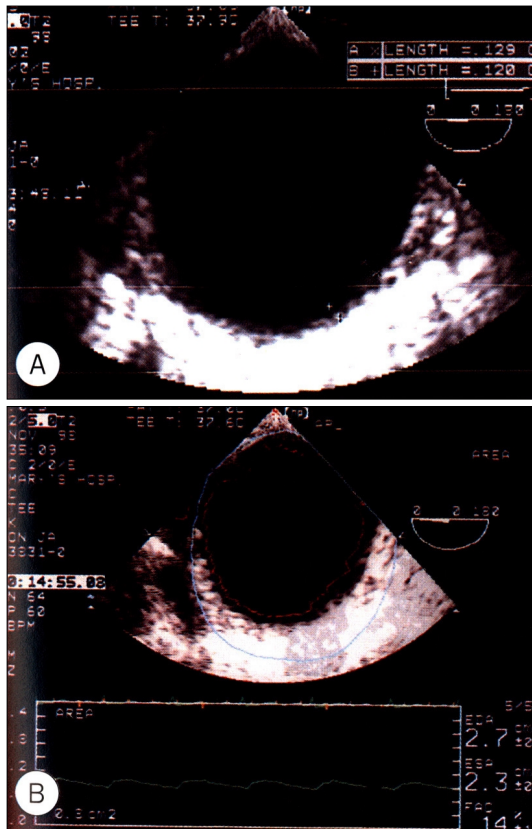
Transesophageal echocardiographic findings of descending aorta in 58 year-old control woman. A : The intimal-medial thickness of descending thoracic aorta was about 1.2 mm. B : Fractional area change of this patient measured by acoustic quantification was 14%.
